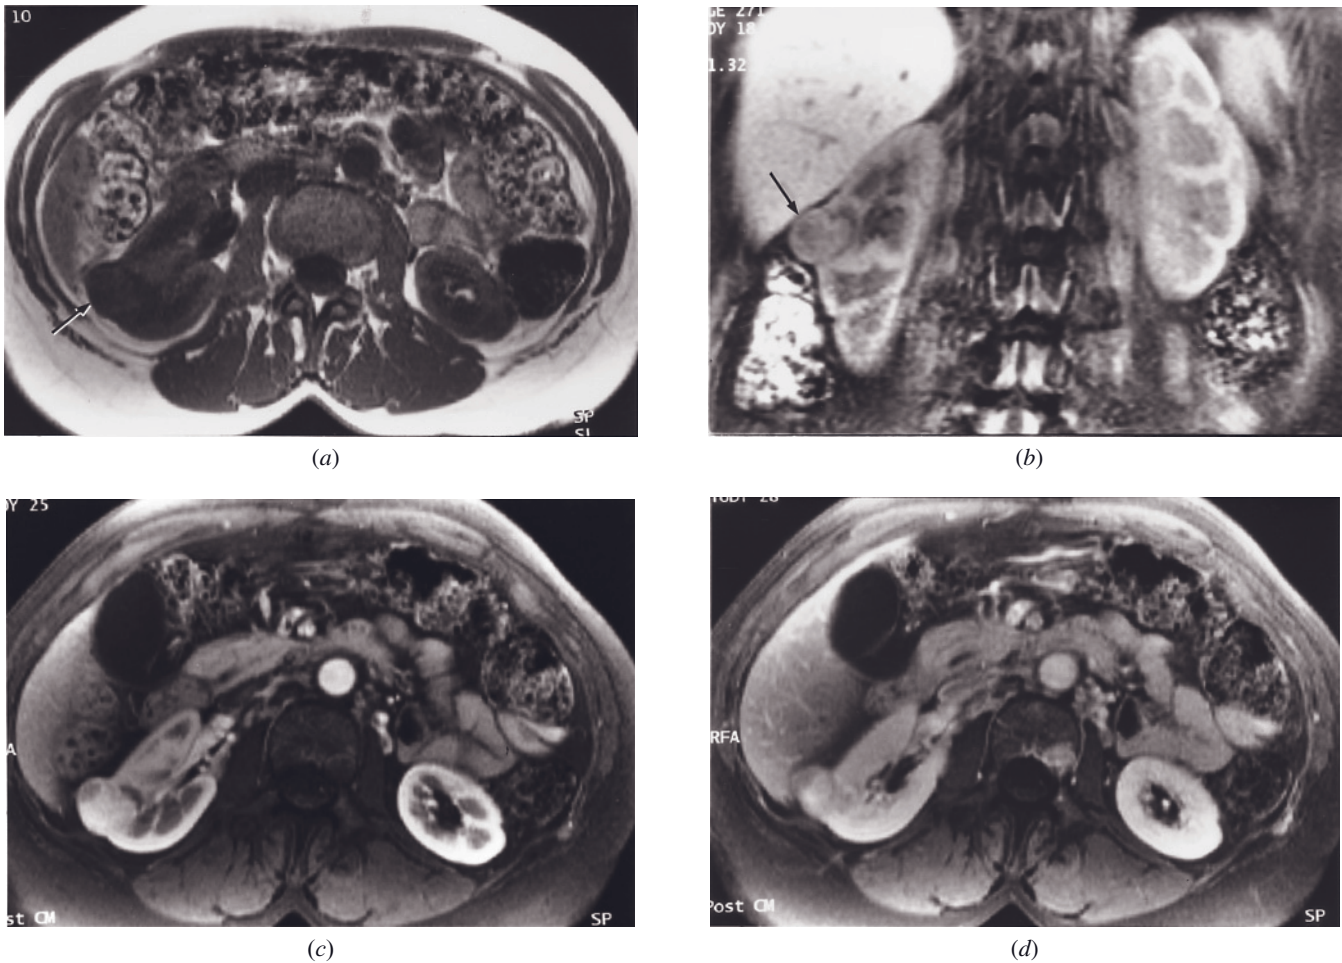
Renal oncocyoma. Transverse T1-weighted precontrast SGE (*a*), coronal T1-weighted precontrast fat-suppressed SGE (*b*), and T1-weighted immediate (*c*) and 90-s fat suppressed (*d*) gadolinium-enhanced SGE images. A well-defined 2-cm mass is present in the right kidney (arrows, *a, b*). The majority of the tumor enhances in a moderately intense fashion on the immediate postgadolinium image (*c*) and shows mild peripheral washout by 90s (*d*). The appearance is indistinguishable from that of a small renal cancer.
